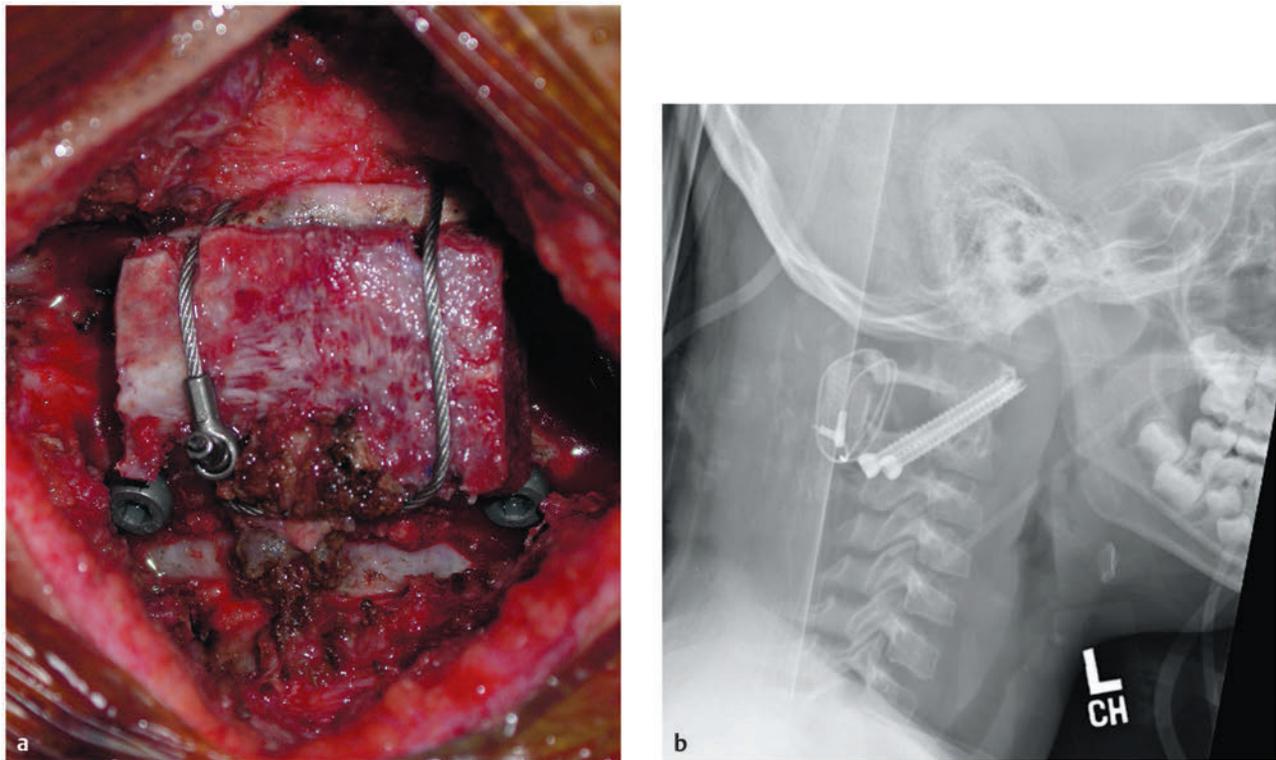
Atlantoaxial rotatory subluxation (AARS). (a) Intraoperative photograph and (b) postoperative lateral radiograph of the fusion construct performed in the patient from ► Fig. 61.5 with refractory AARS. Following open reduction under general anesthesia, stabilization was achieved with bilateral C1–2 transarticular screws, and an iliac crest bone graft was cabled in Sonntag-Dickman fashion between the posterior arches of C1 and C2.⁶⁵
